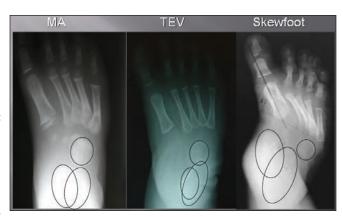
Comparative AP radiographs of metatarsus adductus, talipes equinovarus, and skewfoot, outlining the salient tarsal relationships and position relative to the cuboid and forefoot.
